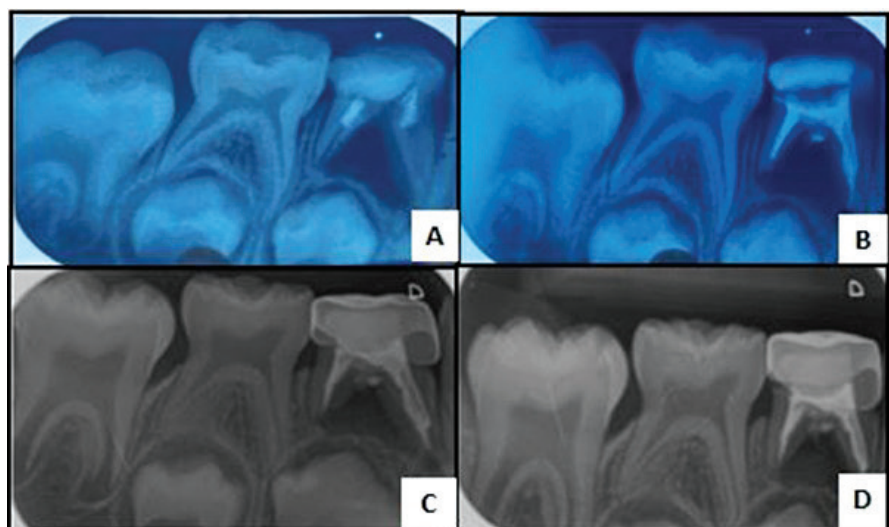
Radiographic follow up: A) Pre-op. B) 3-month follow-up; C) 6-month follow-up; D) 1 year follow up
